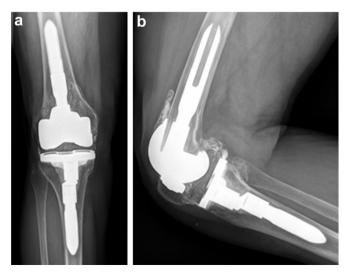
AP (a) and lateral (b) radiograph of the right LEGION TKA showing metallosis and a metal-backed patellar component. TKA, total knee arthroplasty.
